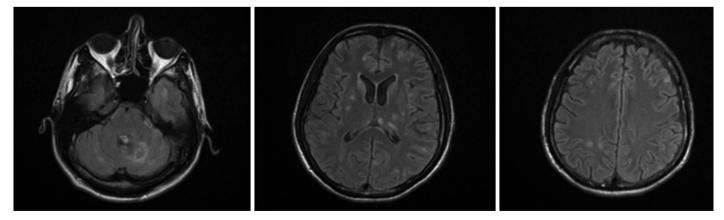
FLAIR-weighted images of patient 3 with cerebral toxoplasmosis after treatment *FLAIR: Fluid-attenuated inversion recovery*
